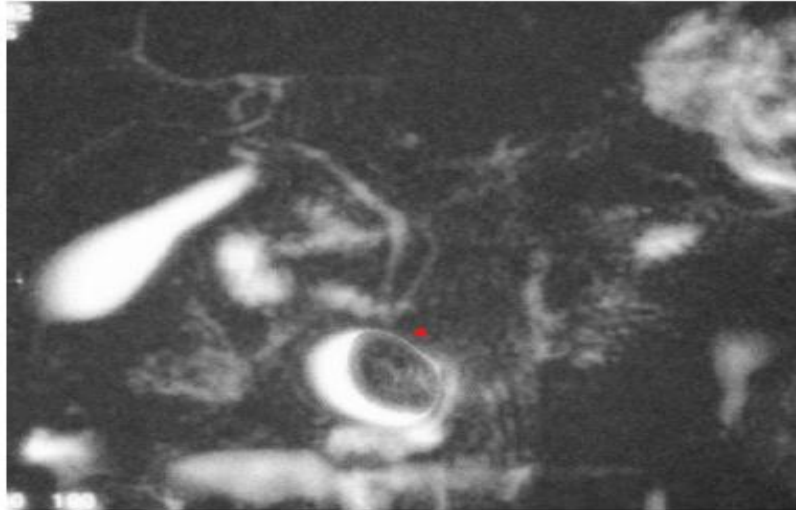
Bili MRI; Cystic dilatation of the bile duct type III of TODANI with Macrolithiasis.
